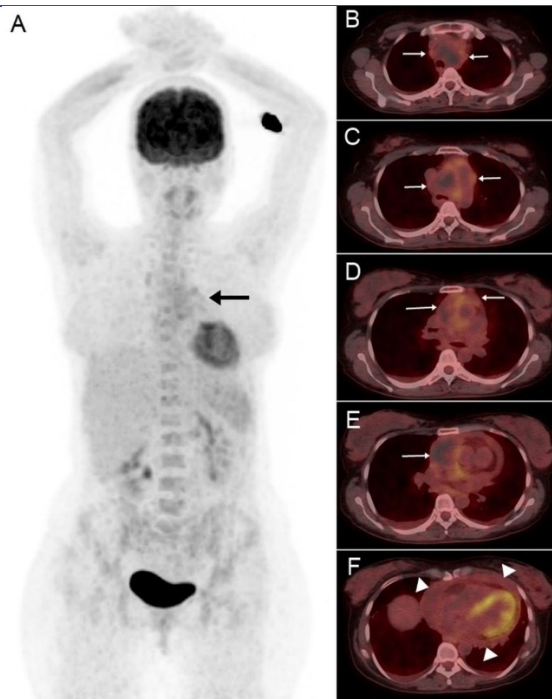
Maximum intensity projection (MIP) image (A) and axial fused [¹⁸F]FDG PET/CT images (B–F)
